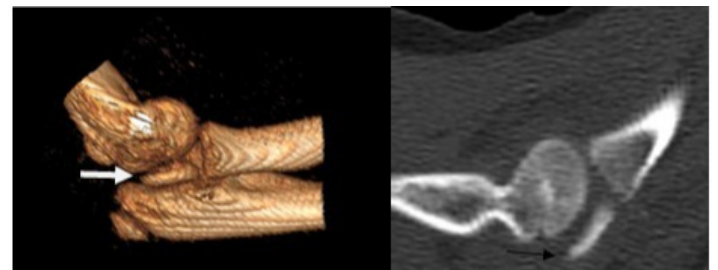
3D reconstruction and CT scan (sagittal split). Displaced radial head (arrow).
